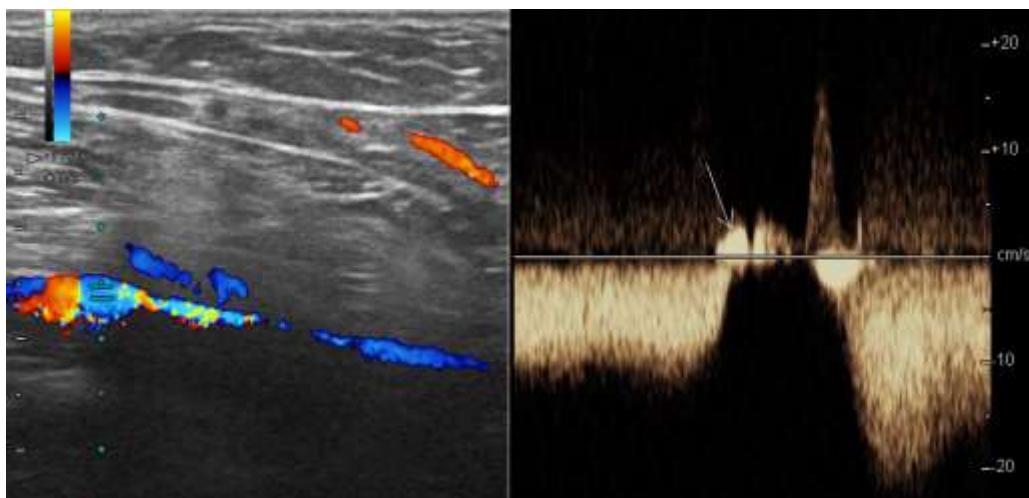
Sonogram of deep shin vein, USDS. Performed with distal compression test.
